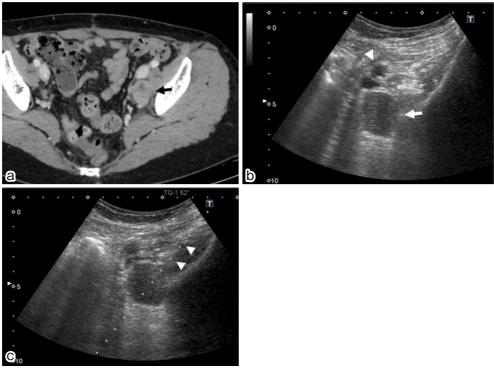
Biopsy for obturator lymphadenopathy.3a. Computed tomography showing the obturator lymphadenopathy (arrow).3b. Ultrasound (US) showing obturator lymphadenopathy (arrow) and external iliac artery (arrowhead).
